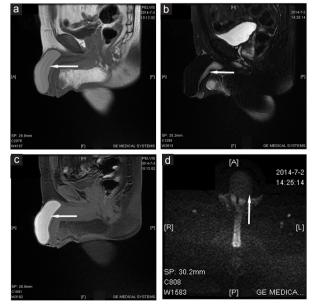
MRI of the penis. (a) Isointense or slight hypointensity on T1WI. (b) Hypointense on T2WI + FS. (c) Hypointensity on T1WI + FS. (d) Isointense or slight hypointensity on DWI. MRI: magnetic resonance imaging; T1WI: T1 weighted imaging; T2WI: T2 weighted imaging; FS: fat suppression; DWI: diffusion weighted imaging.
